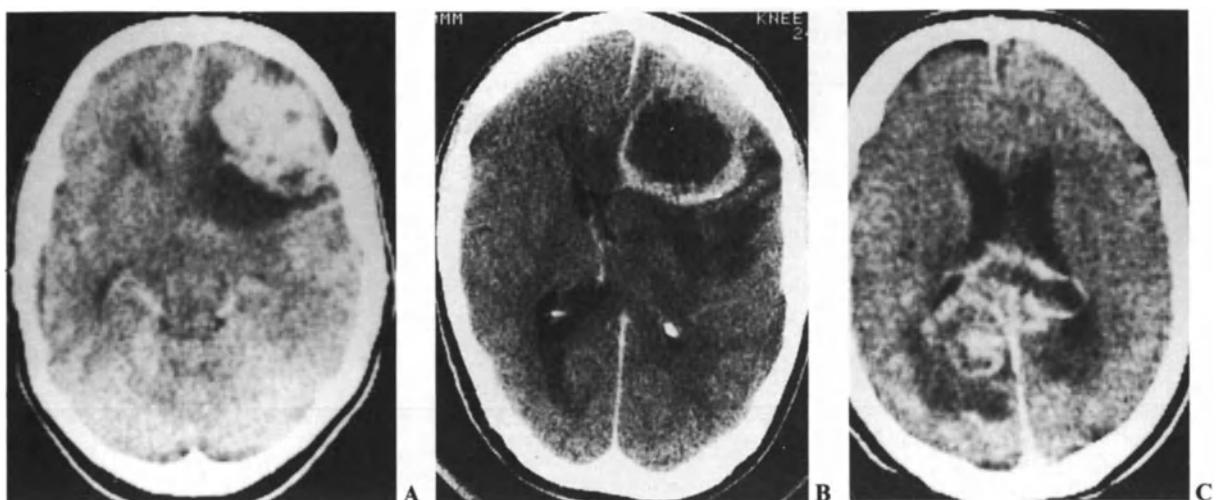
Post-enhancement CT in malignant gliomas. A Largely homogeneous enhancement with surrounding edema. B Marginal enhancement with posterior edema showing digital pattern. C Serpiginous enhancement pattern extending bilaterally through corpus callosum with surrounding edema.
